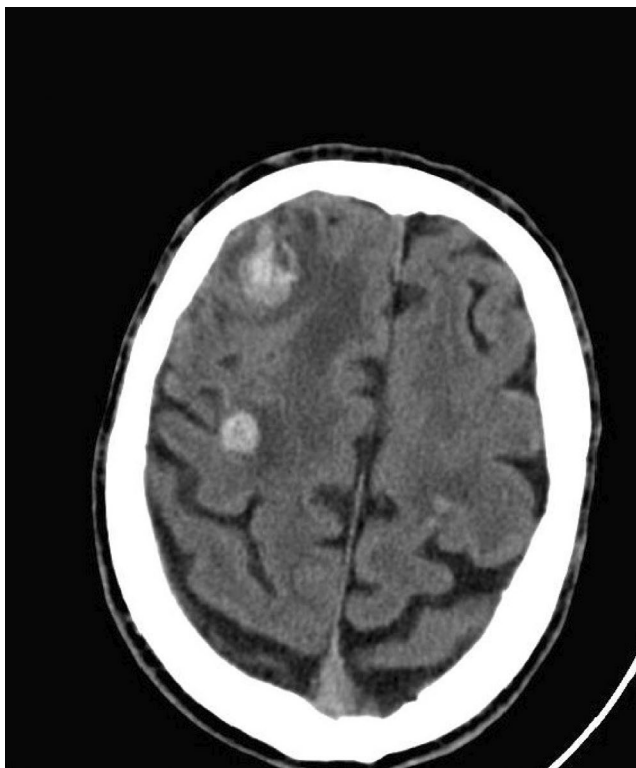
CASE 2 Noncontrast enhanced computed tomography revealing several intraparenchymal hyperdense rounded lesions and surrounding vasogenic edema.
